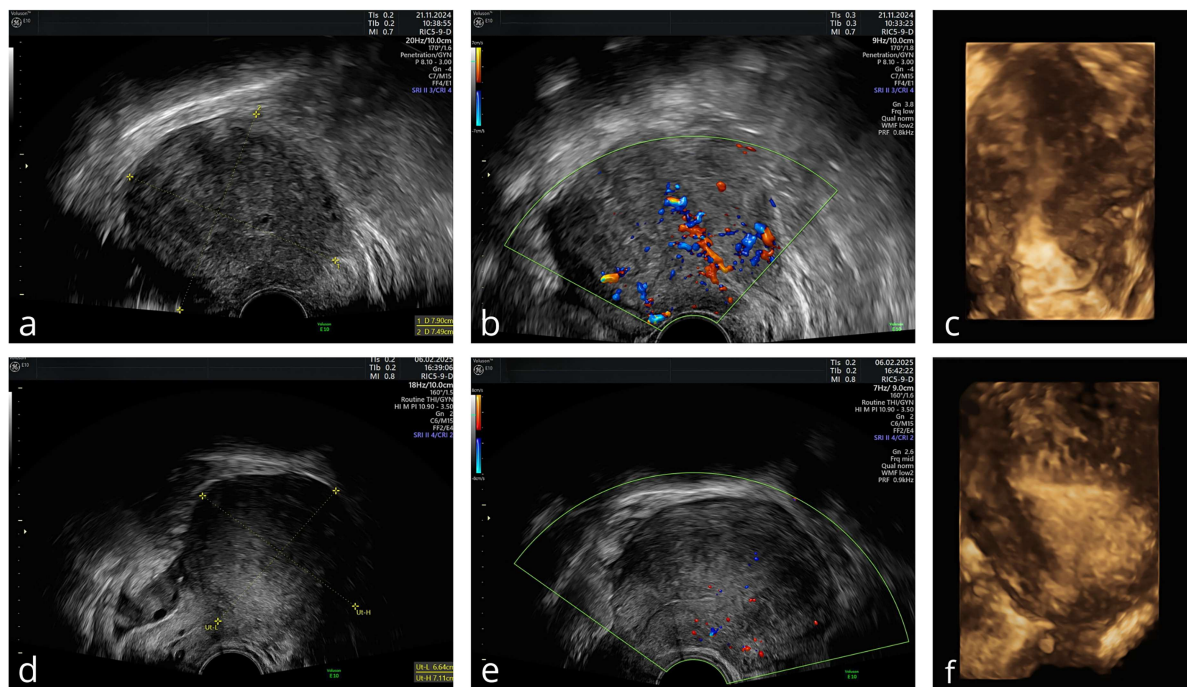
Transvaginal ultrasound evaluation of the uterus in Case 2. (a) Baseline two-dimensional grayscale image showing a markedly enlarged, globular uterus with diffuse myometrial heterogeneity. Notable direct signs of adenomyosis are present, including hyperechogenic islands, subendometrial echogenic lines and buds, and small myometrial cysts. (b) Color Doppler ultrasound at baseline revealed scattered intramyometrial vascularity (color score 3). (c) Baseline 3D ultrasound reconstruction showing an irregular junctional zone with a distorted endometrial-myometrial interface. (d) Follow-up grayscale ultrasound after 12 months of treatment, showing a reduction in uterine dimensions and improved myometrial echotexture. (e) Color Doppler at follow-up demonstrating reduced vascularization (color score 2). (f) 3D ultrasound at 12 months displaying a less distorted uterine contour and partial restoration of the junctional zone.
